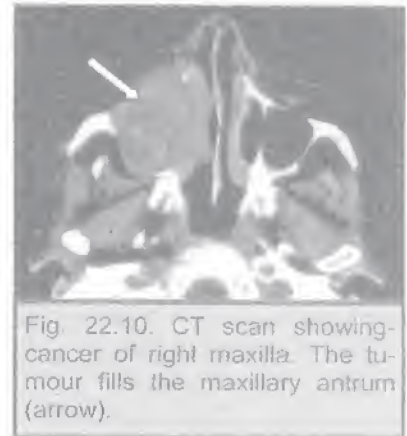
CT scan showing cancer of right maxilla. The tumour fills the maxillary antrum (arrow).
